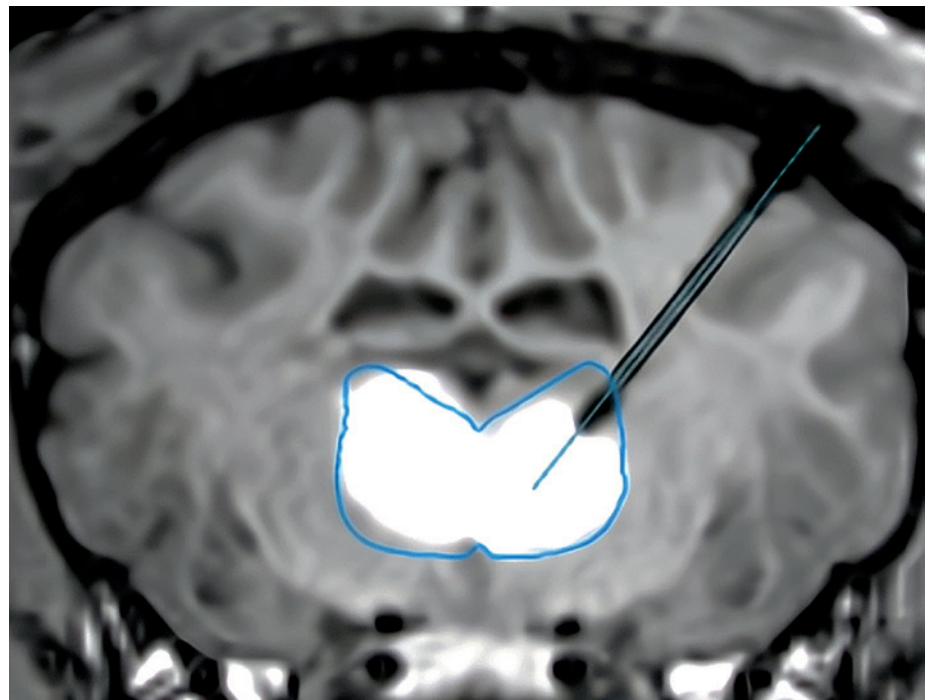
Magnetic resonance imaging (MRI) showing a real-time infusion into the thalamus using the Neurochase Acute Drug Delivery System of a gene therapy co-labelled with MRI contrast agent gadolinium to enhance visibility.
